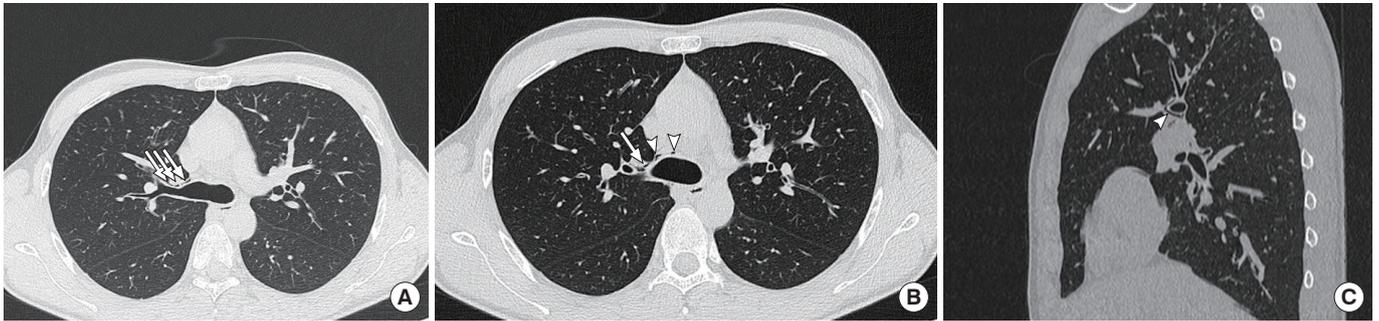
Axial chest computed tomography image (lung window) showing (A) linear collection of air (arrows) adjacent to the bronchovascular sheath (Macklin effect) and (B) centripetal spread of air along the bronchovascular sheath to the right hilum (arrow) and to the mediastinum (arrowheads). (C) Sagittal chest computed tomography image (lung window) showing the presence of air around the right main bronchus (arrowheads).
